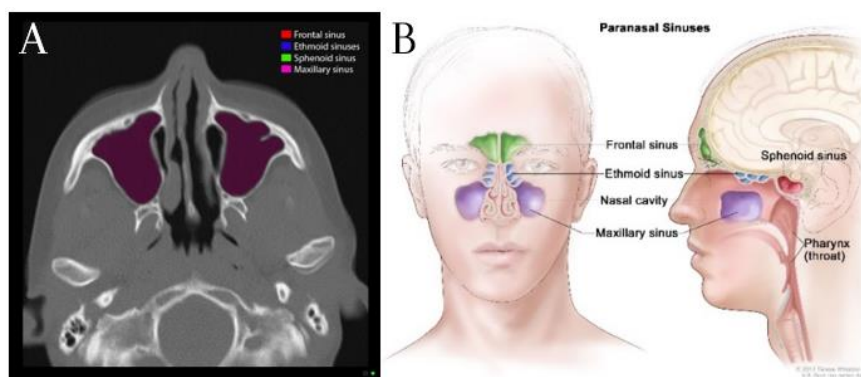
Maxillary sinuses are highlighted in purple in the cross-sectional CT scan (A), and they are depicted together with the other paranasal sinuses (B).^{7,8}
